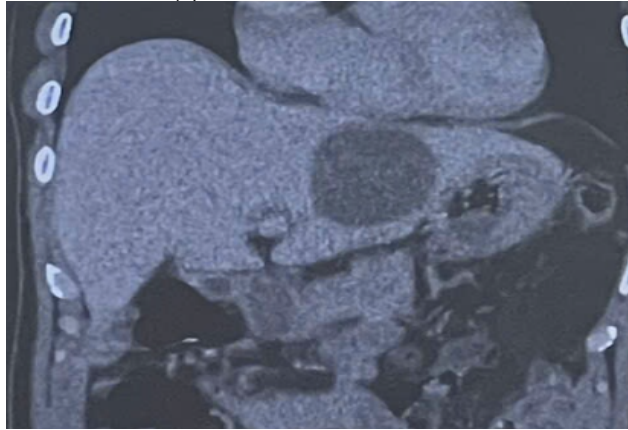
Imaging of the left-lobe hepatic cyst on abdominal CT.
